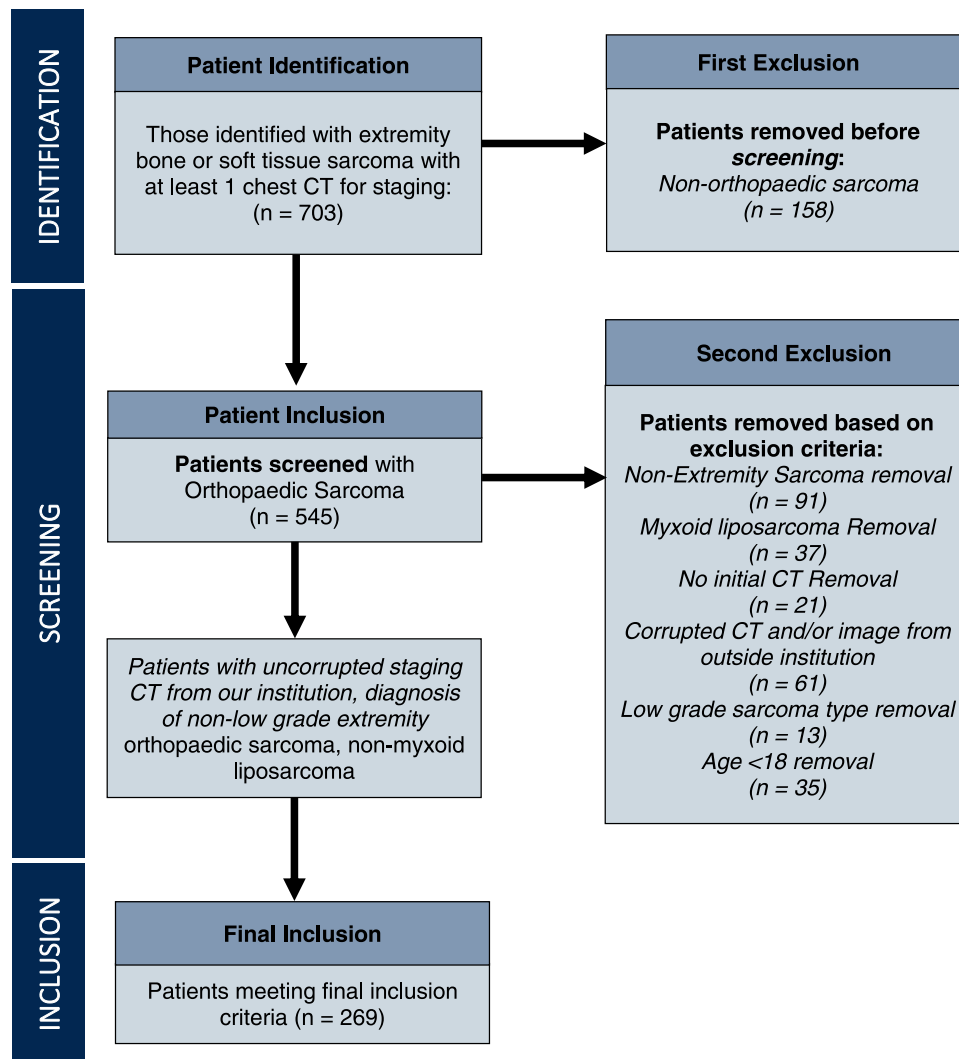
Study cohort inclusion and exclusion criteria. CT, computed tomography.
